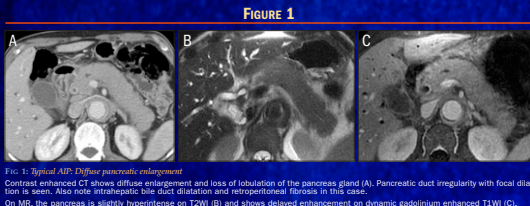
Typical AIP: Diffuse pancreatic enlargement. Contrast enhanced CT shows diffuse enlargement and loss of lobulation of the pancreas gland (A). Pancreatic duct irregularly with focal dilation is seen. Also note intrahepatic bile duct dilatation and retroperitoneal fibrosis in this case. On MR, the pancreas is slightly hypointense on T2WI (B) and shows delayed enhancement on dynamic gadolinium enhanced T1WI (C).
